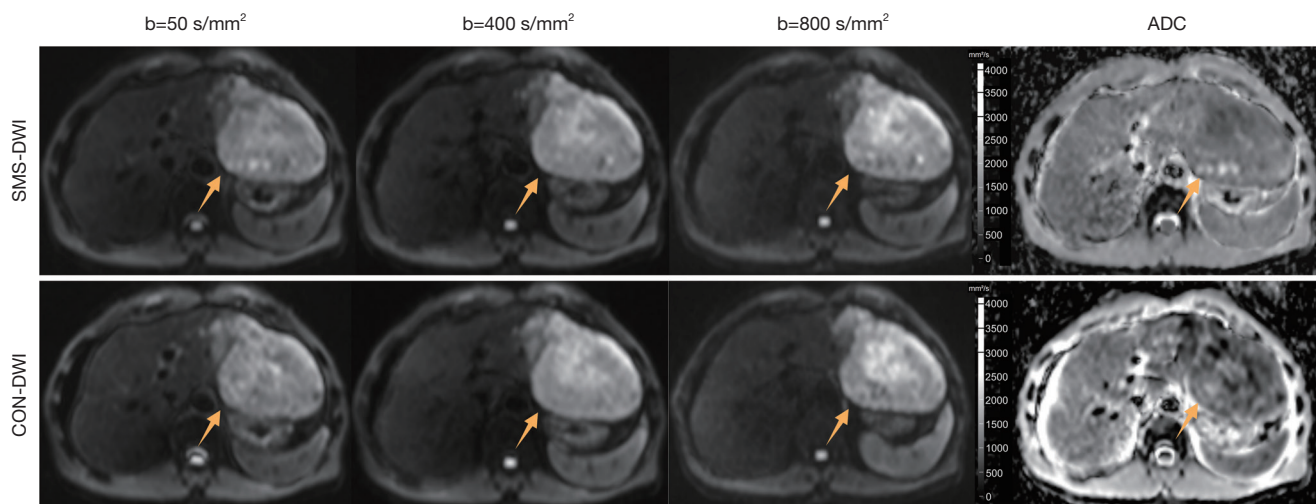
Representative images with SMS-DWI (upper row) and CON-DWI (lower row) of a 58-year-old male patient with pathologically confirmed hepatocellular carcinoma. Diffusion-weighted trace images with three different b-values ($b=50$, $b=400$, $b=800$ s/mm²) and the corresponding ADC maps are shown, with the arrows pointing to the lesion. The average ADC measurements were 1.10×10^{-3} mm²/s in SMS-DWI and 1.14×10^{-3} mm²/s in CON-DWI. SMS, simultaneous multislice; DWI, diffusion-weighted imaging; ADC, apparent diffusion coefficient; CON, conventional.
